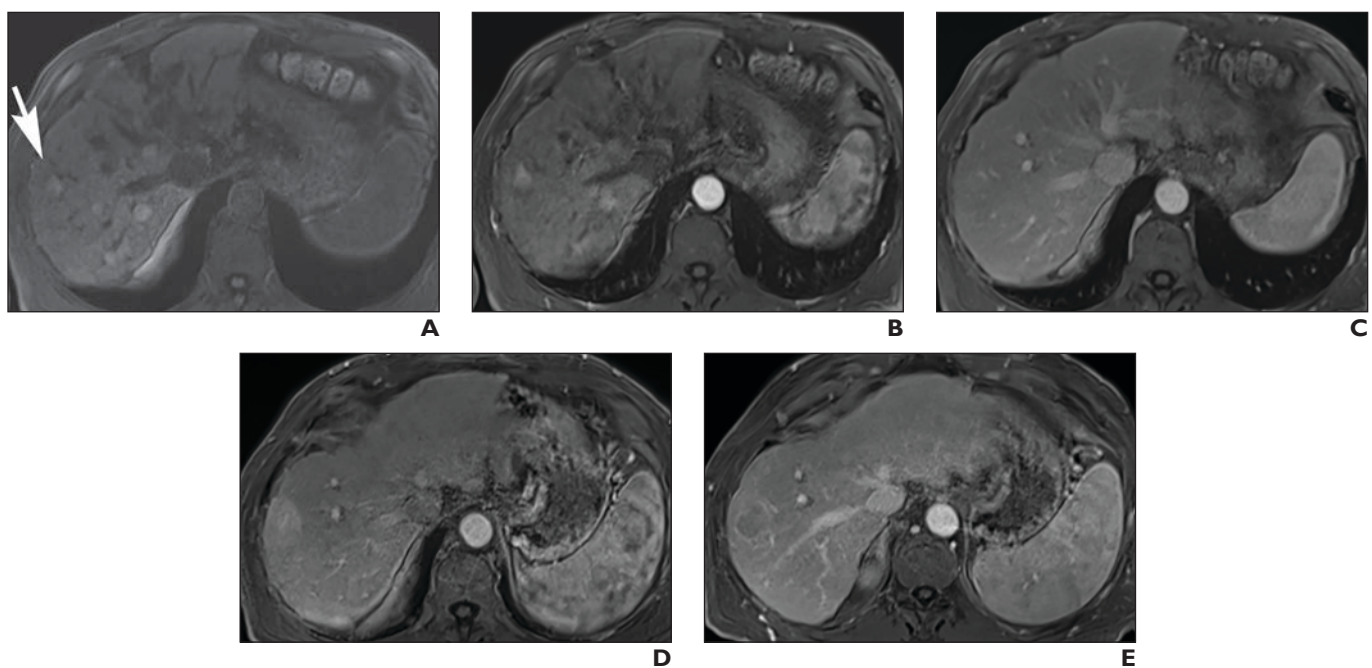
62-year-old man with alcoholic cirrhosis and hepatocellular carcinoma (HCC). Example of distinctive nodule that develops into HCC. Initial MR images of atypical nodules (arrow, A) show increased signal intensity on T1-weighted images and isointensity on T2-weighted images (not shown) with questionable enhancement on early arterial phase images (A–C) without washout. Four months later (D and E), lesion in subcapsular portion of segment VIII exhibits arterial phase enhancement and washout and measures larger than 2 cm.
